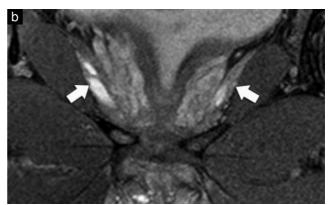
Pubic symphysis capsule rupture and bilateral levator ani tear in a 39-year-old woman after a 'low-risk' vaginal delivery. Proton density-weighted magnetic resonance images with fat saturation: (a) coronal plane, mid symphysis; (b) coronal plane, posterior to symphysis; and (c) sagittal plane, right parasymphysis. Images (a) and (c) show distension of superior and inferior joint capsule with rupture (black arrow) along right side. Fluid tracks into both levator ani muscles (b), which are partially torn (white arrows).
